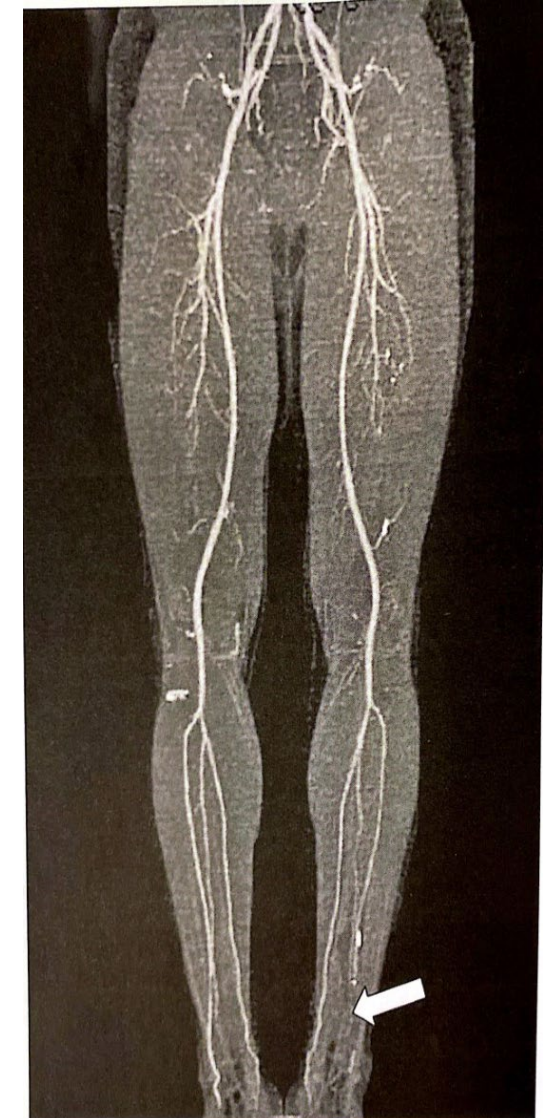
A high-resolution computed tomography angiography of a patient with normal right lower extremity arterial circulation. Distal occlusive disease is noted in the left tibial arteries (arrow).
